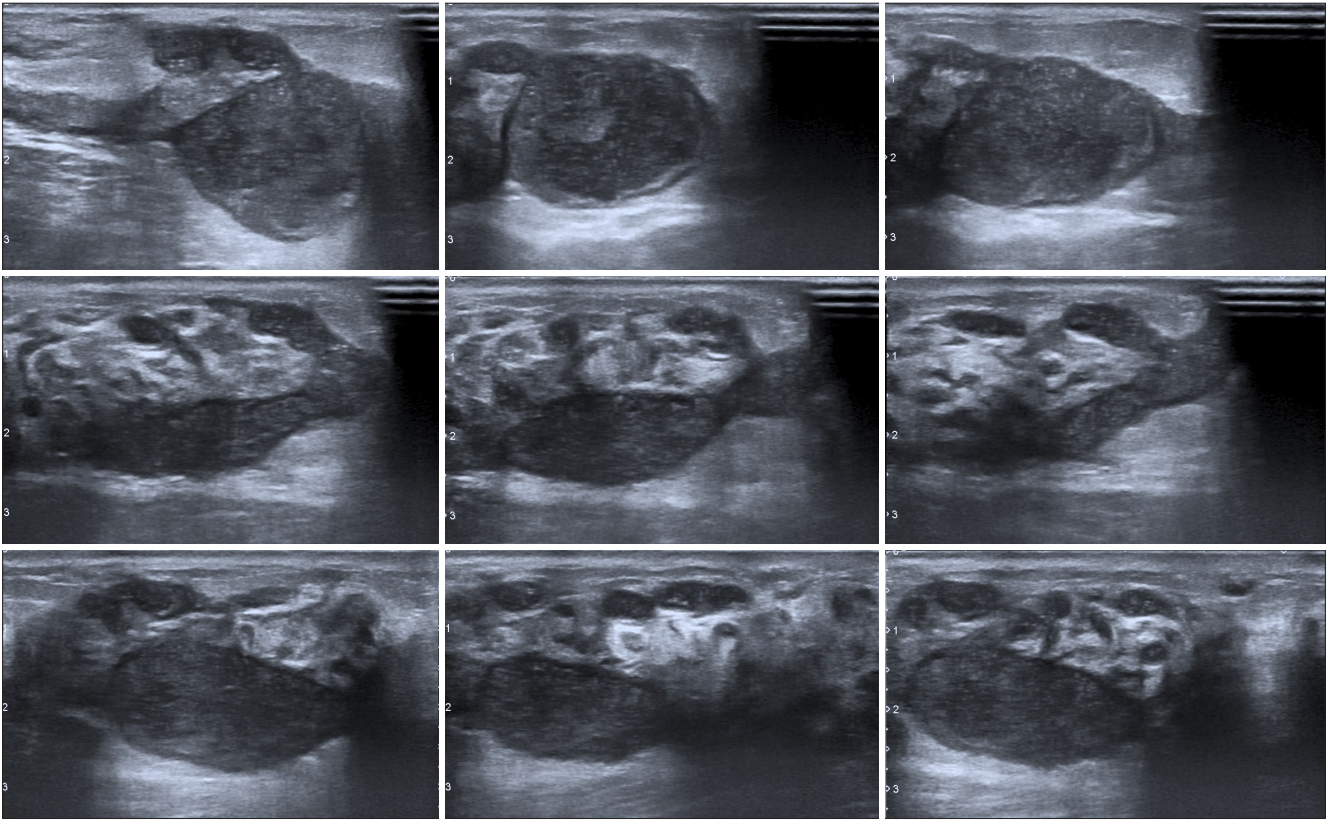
Ultrasound images of a patient with hypoechoic masses containing internal echoes with tubular extensions
